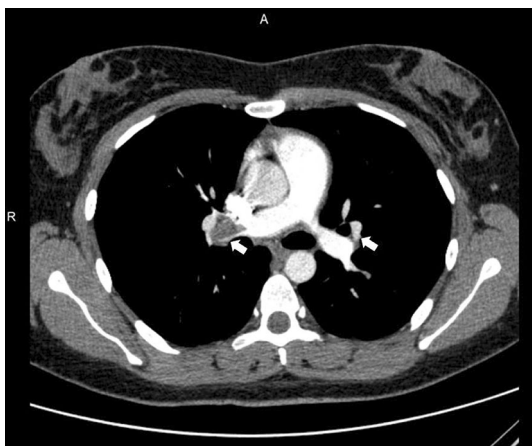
Computed tomographic pulmonary angiography, showing segmentar and subsegmentar bilateral pulmonary embolism. *R* right, *A* anterior
